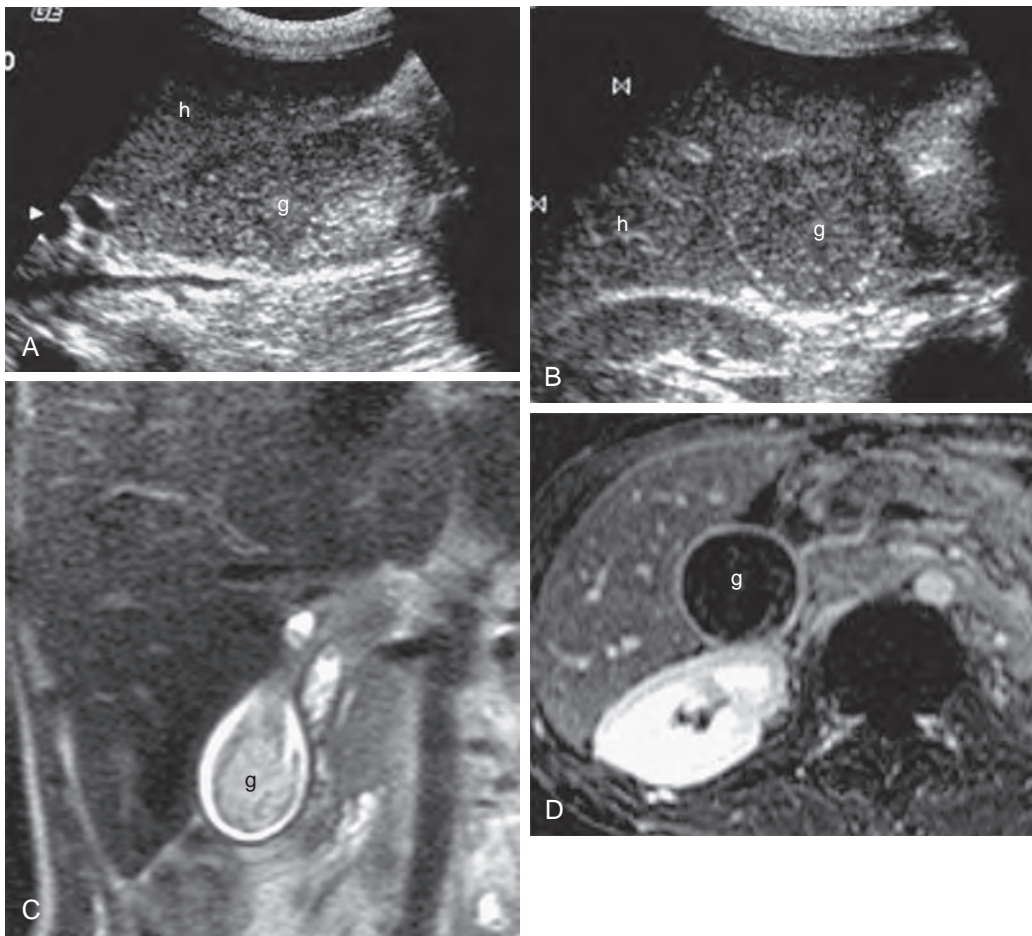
Sludge-filled gallbladder: sonography and MR features. Sagittal (A) and transverse (B) sonograms demonstrate gallbladder lumen (g) filled with echogenic material. The echotexture is similar to that of the adjacent liver parenchyma (h). This appearance is referred to as hepatization of the gallbladder. C. Coronal T2-weighted HASTE MR image demonstrates intermediate signal intensity material in the gallbladder lumen (g). D. Axial contrast-enhanced T1-weighted fat-suppressed MR image with subtraction shows no enhancement of gallbladder lumen (g), excluding an intraluminal mass.
